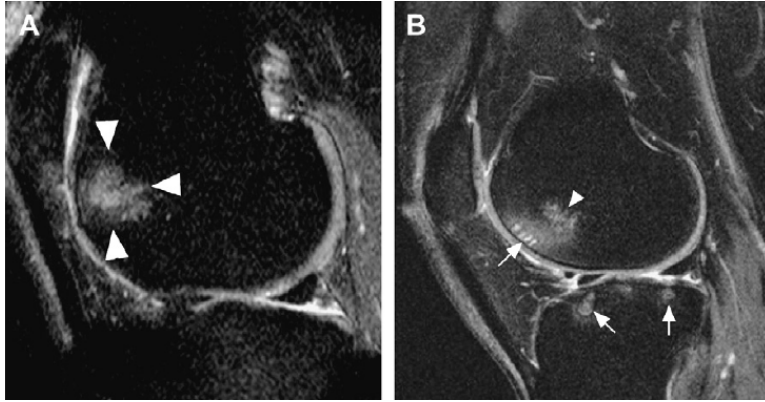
Examples of 1.0 T and 3.0 T MR imaging of knee OA. (A) Sagittal proton density-weighted fat-suppressed 1.0 T MR image shows a subchondral BML in the anterior medial femur (arrowheads) associated with superficial cartilage damage. (B) Sagittal proton density-weighted fat-suppressed 3.0 T MR image shows a subchondral BML in the anterior lateral femur (arrowhead) and femoral and tibial subchondral cysts (arrows).
